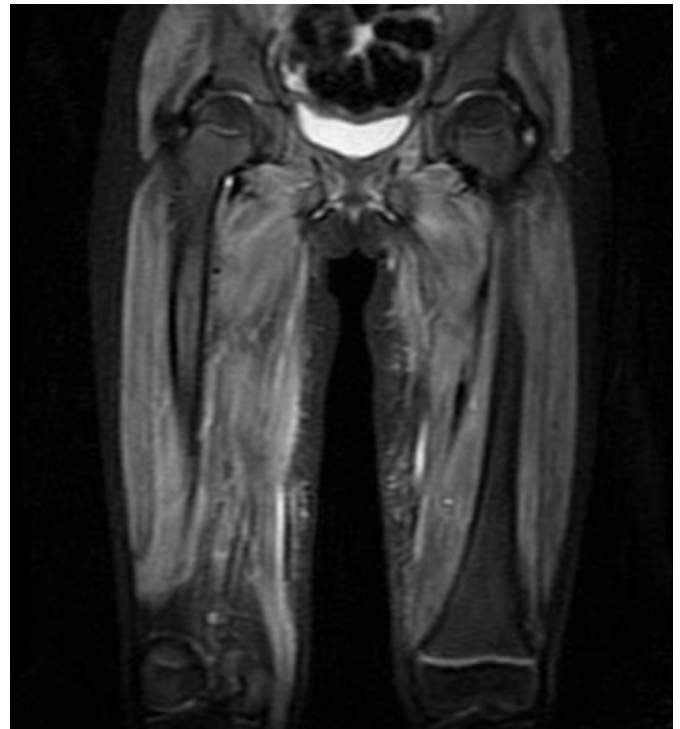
Hyperintense signal at all of the girdle muscle on T2 weighted images on MRI.
